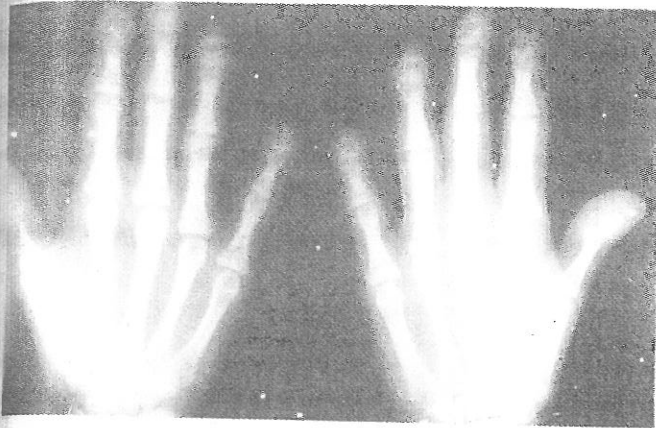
X-ray hands showing central acro-osteolysis with "half-moon cut" called "slice-effect"
